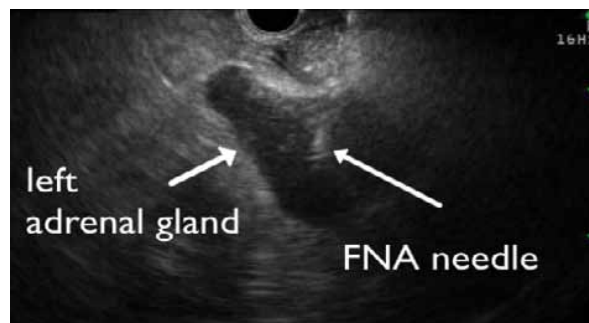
Transgastric endoscopic ultrasound–fine-needle aspiration (FNA) of the left adrenal gland.
